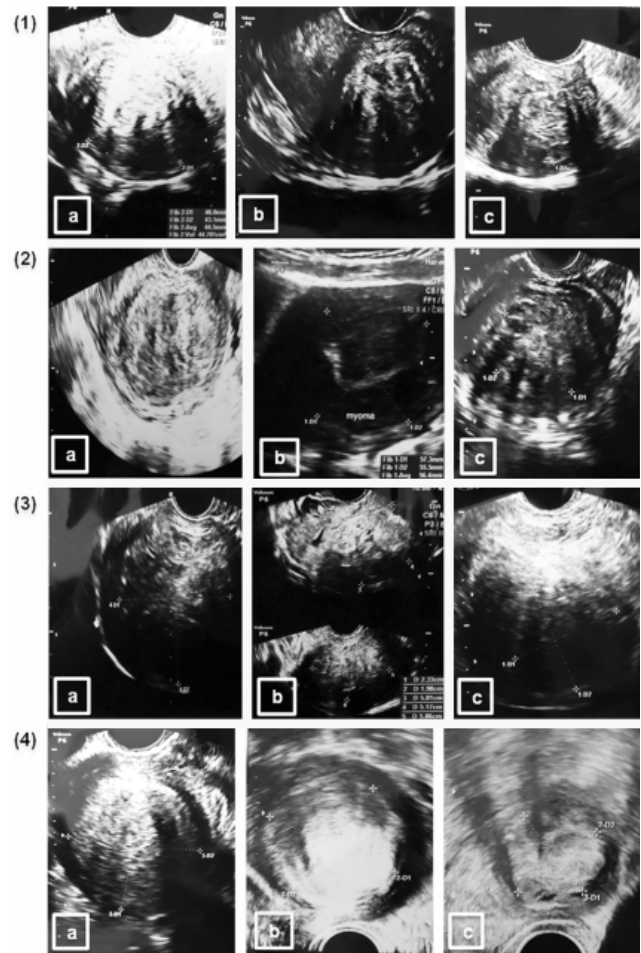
Pelvic ultrasound Case 1 (1), Case 2 (2), Case 3 (3), Case 4 (4) before RFA (a), after 1 week post RFA (b), after 3 months post RFA (c)
